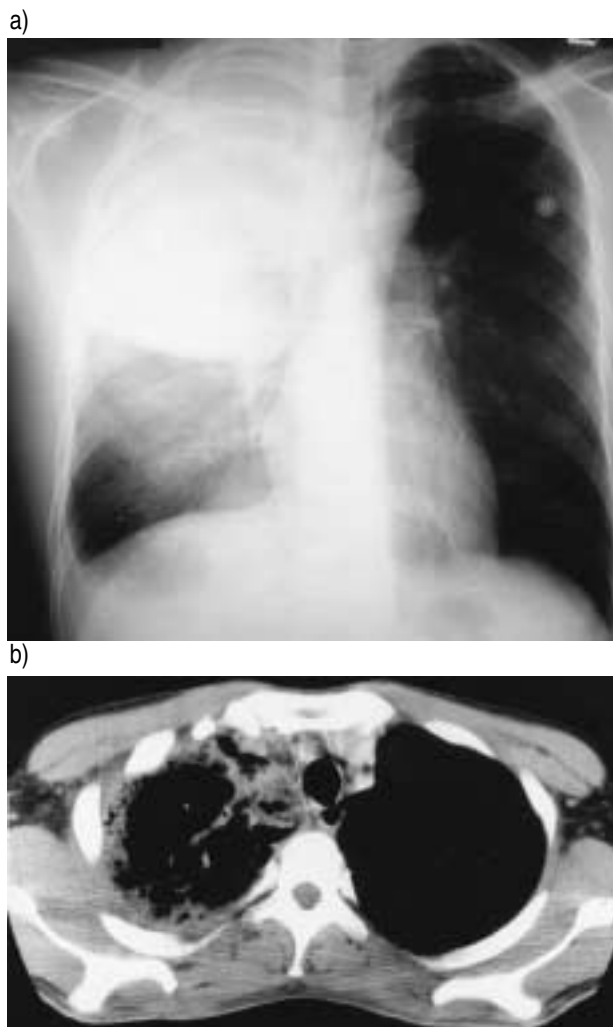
a) Chest radiograph of the patient showing lobar consolidation of the right upper and partly lower lobe with bulging fissure. b) Computed tomographic scan showing necrotizing lobar pneumonia involving the superior mediastinum, and poor enhancement of the right brachiocephalic vein.
